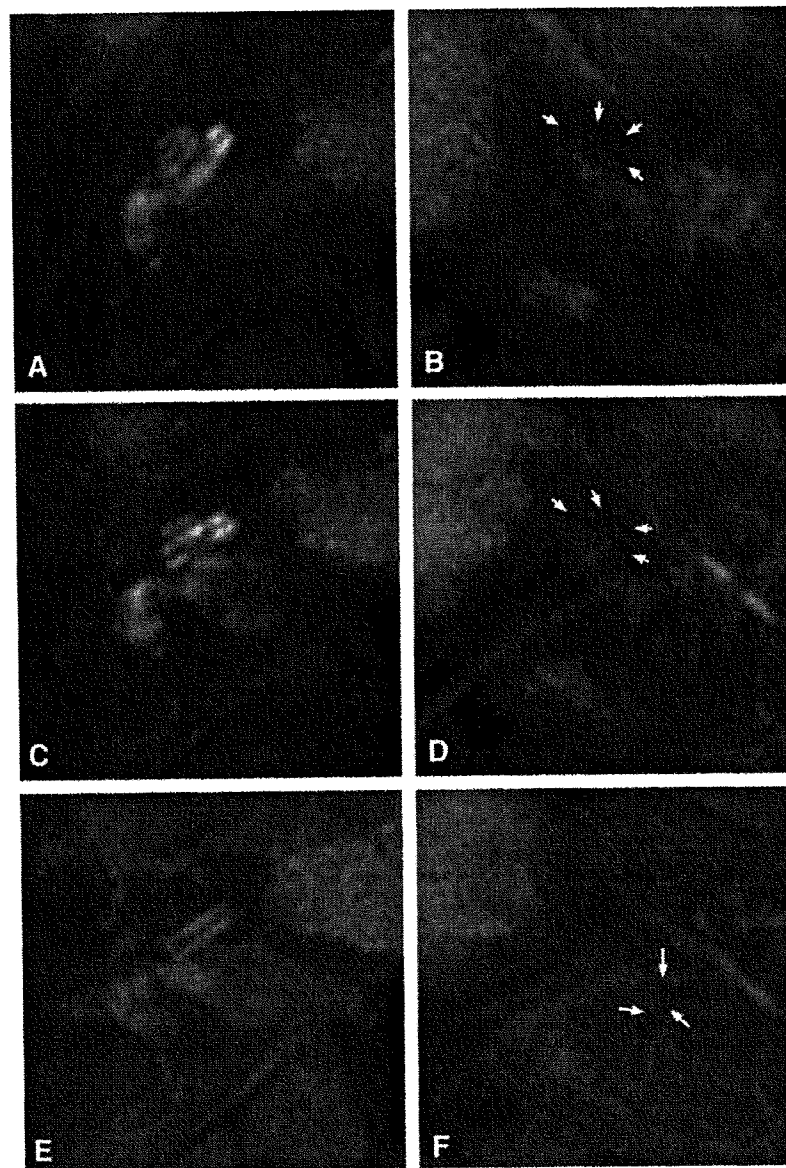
Consecutive sections of 3D-real IR MRI in case 1. A and B, C and D, and E and F are the same sections. A, C, and E show the right ear; B, D, and F show the left ear. Significant endolymphatic hydrops was observed in the left ear. Arrows in B and D indicate endolymphatic hydrops in the cochlea (black areas without Gd). Arrows in F indicate endolymphatic hydrops in the vestibule.
